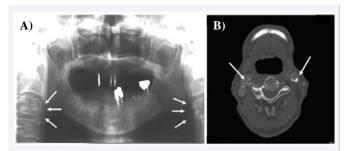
Carotid artery calcification (white arrows) on a dental panoramic radiograph (A) and computed tomography image (B).
